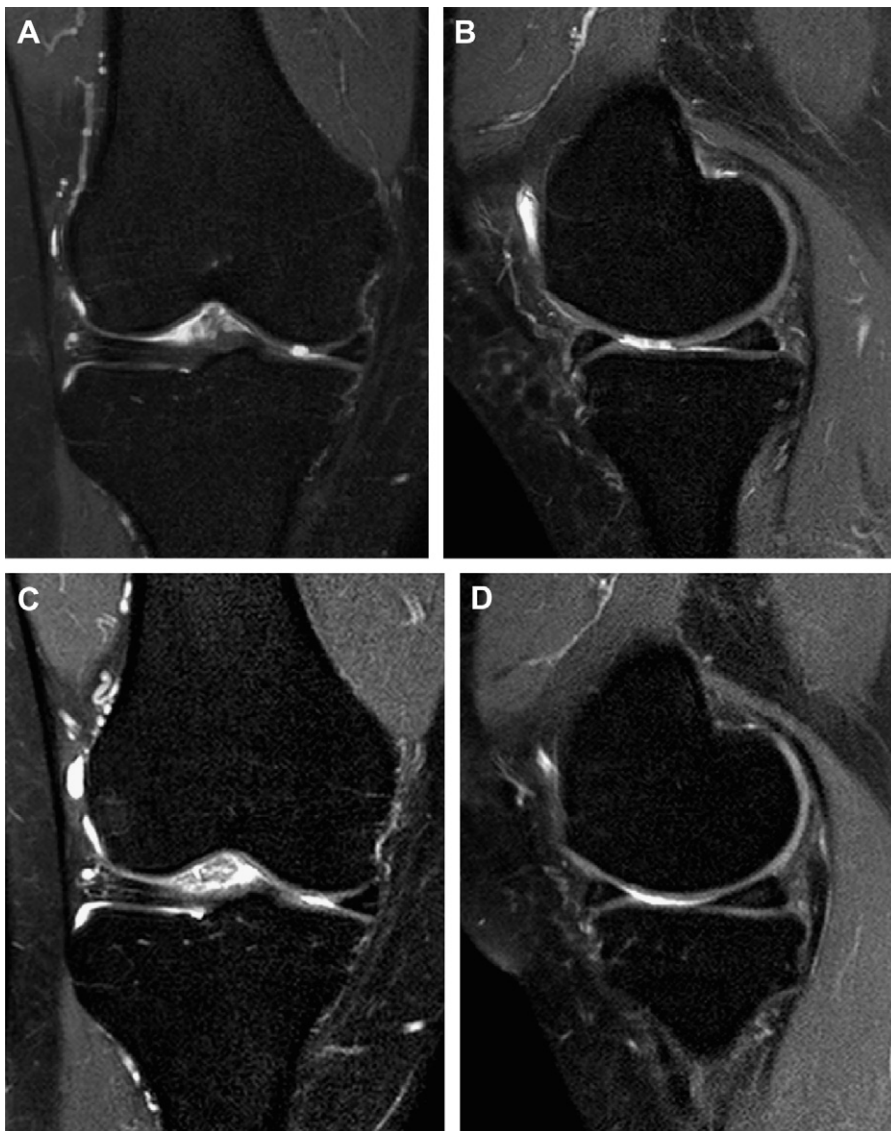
Results of MRI performed preoperatively (A and B) and postoperatively (C and D) on a 45-year-old female patient. This MRI is not representative of all MRIs observed in the study but is explored in further detail because the effects of the treatment were particularly dramatic in this patient. (A) Fat-saturated proton-density fast spin-echo coronal view and (B) T1-weighted fast spin-echo sagittal view of osteochondral defects of medial femoral condyle. (C) Fat-saturated proton-density fast spin-echo coronal view and (D) gradient-echo sagittal view of same patient at 2-year follow-up visit.
